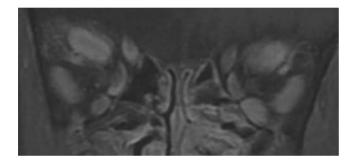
Coronal T1-weighted, fat-suppressed, gadolinium-enhanced magnetic resonance image of enlarged extraocular muscle bellies from vision-threatening thyroidassociated orbitopathy.
